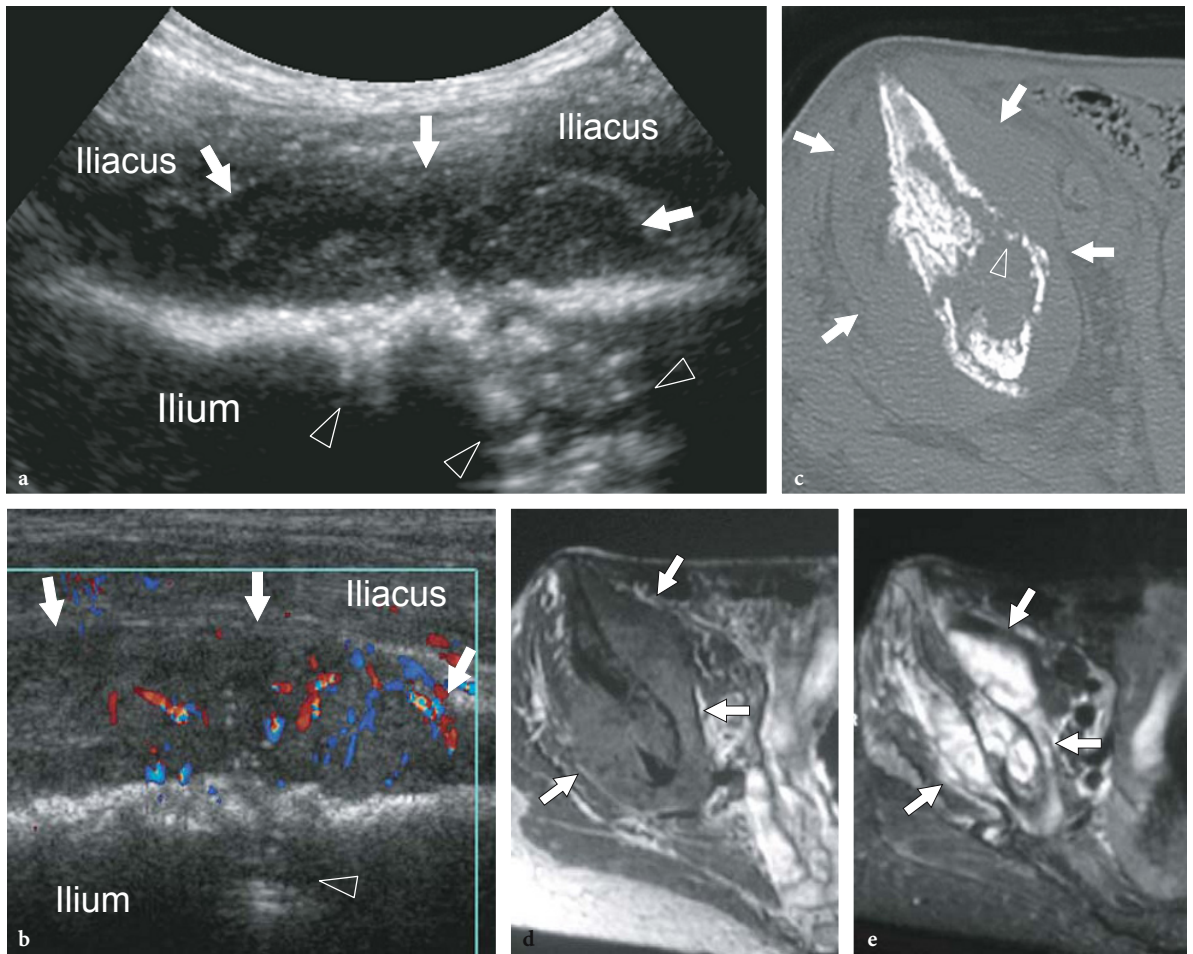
Bone lymphoma. Sagittal a gray-scale and b color Doppler 12–5 MHz US of the right pelvis in a patient complaining of increasing hip pain for 6 months reveal a solid heterogeneous hypoechoic soft-tissue mass (*arrows*) underlying the iliacus muscle associated with signs of bone destruction (*arrowheads*) of the ilium, resembling a pathologic fracture. The mass exhibits a hypervascular pattern with diffuse and irregularly distributed color flow signals. c Transverse CT scan confirms the presence of a large osteolytic lesion of the ilium with pathologic fracture (*arrowhead*). d T1-weighted and e fat-suppressed T2-weighted MR images show the full extent of the lesion in the ilium and the surrounding soft tissues
